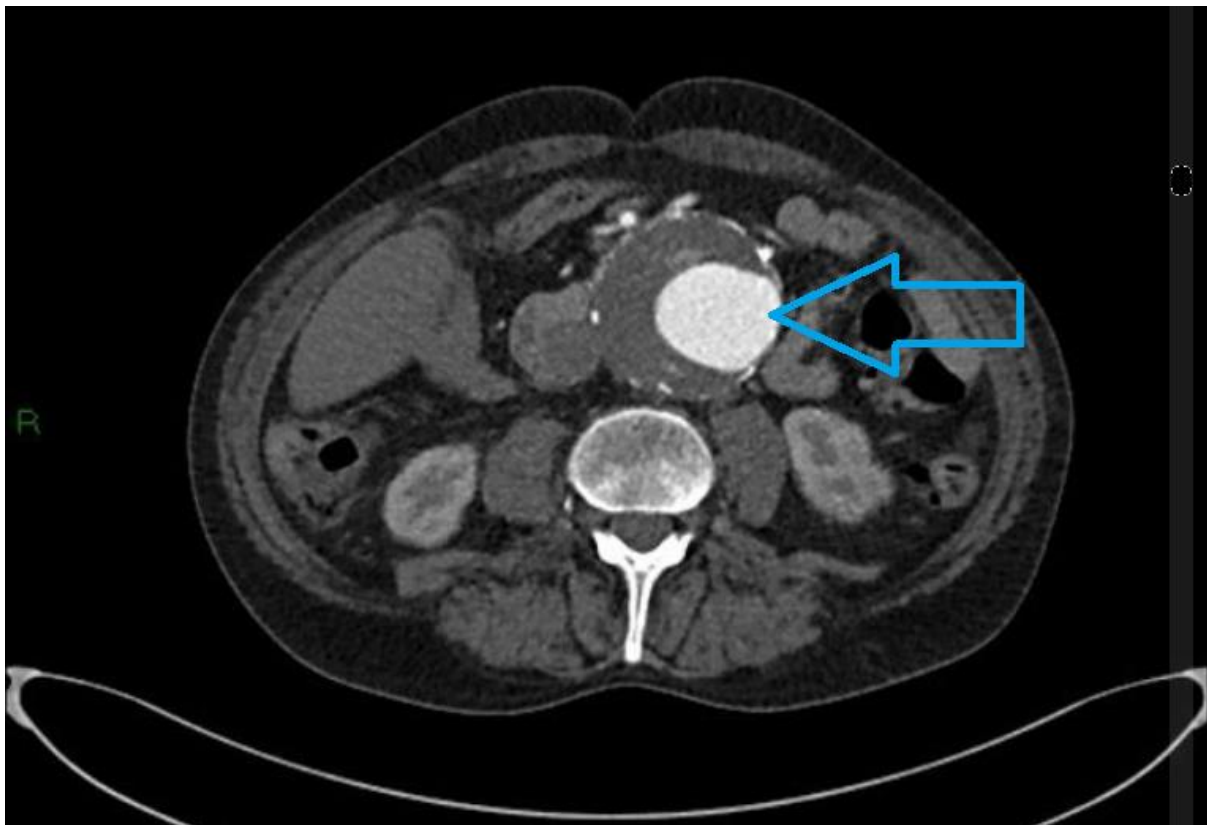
Axial CT scan of 8cm AAA with lumen indicated [28]
